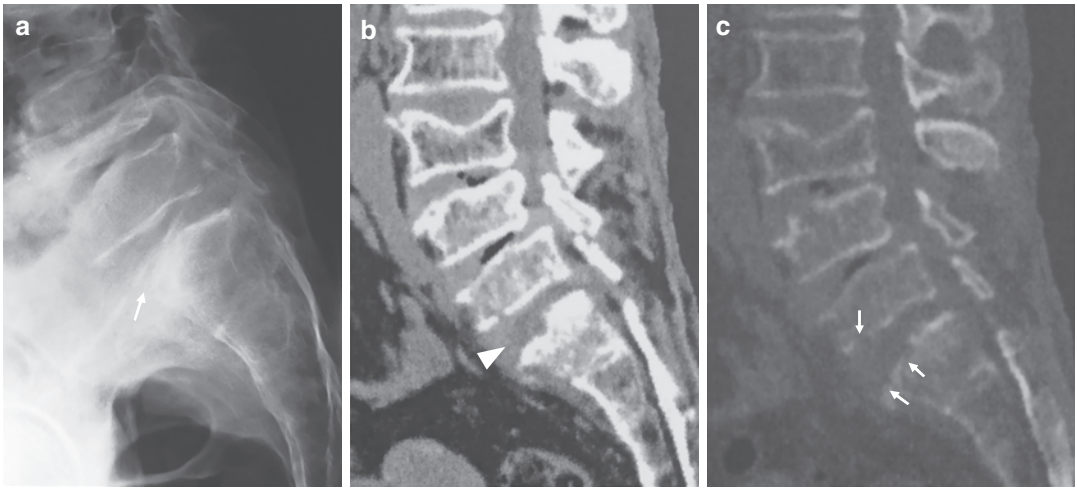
(a) Lateral radiograph of the lumbar spine shows erosion of the anterosuperior corner of S1 segment (white arrow). (b, c) Sagittal CT images of the same
